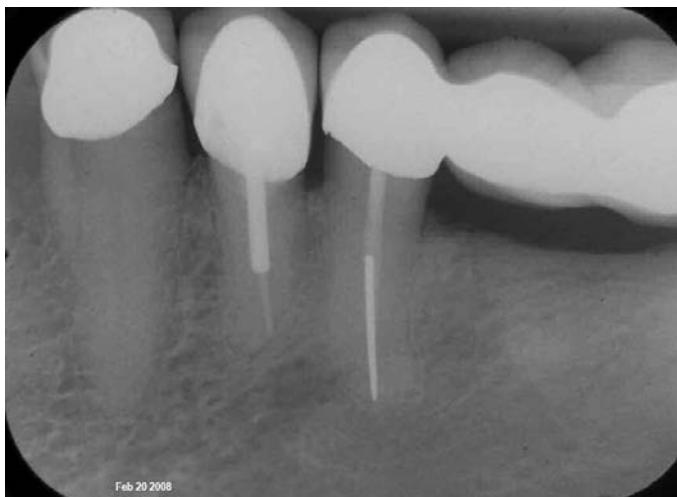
Radiograph after cementation, crown margin close to crestal bone.
